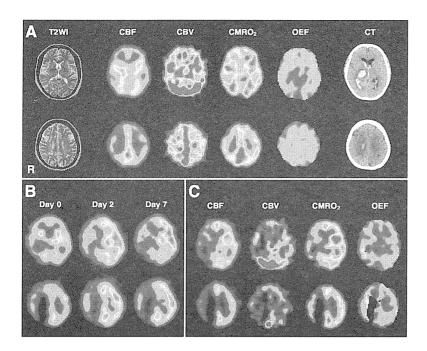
Radiological finding of a 52-year-old woman who was diagnosed as moyamoya disease because of transient weakness of bilateral extremities. A, Preoperative examinations revealed a marked decrease of cerebral blood flow (CBF) and an increase of cerebral blood volume (CBV) and oxygen extraction fraction (OEF) in the bilateral frontal lobes, although MRI demonstrated no cerebral infarction. Several days later, she developed intracerebral hemorrhage in the right thalamus. Approximately 6 months later, she underwent bypass surgery on the left side. B, Postoperative serial single photon emission CT (SPECT) reveals significant improvement of CBF just after surgery, but a marked hyperperfusion in the left frontal lobe 2 days and 7 days after surgery. She developed motor aphasia 2 days after surgery. C, One month after surgery, positron emission tomography scan showed the normalization of CBF, CBV, and OEF in the left hemisphere.
